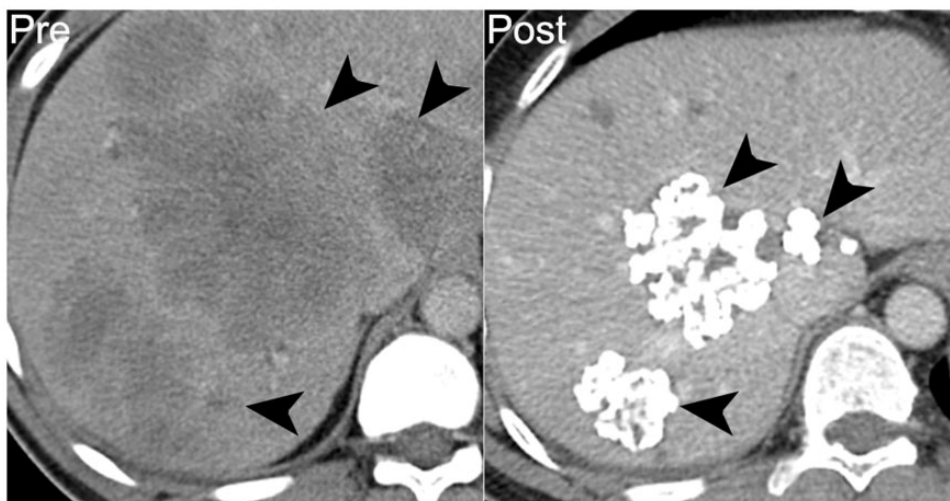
A 43-year-old man with high-risk jejunal GIST. Prior to treatment, axial noncontrast CT image shows diffuse hypodense hepatic metastases (arrowheads on left). After 6 years of treatment with imatinib mesylate, treated hepatic lesions are smaller and densely calcified (arrowheads on right).
